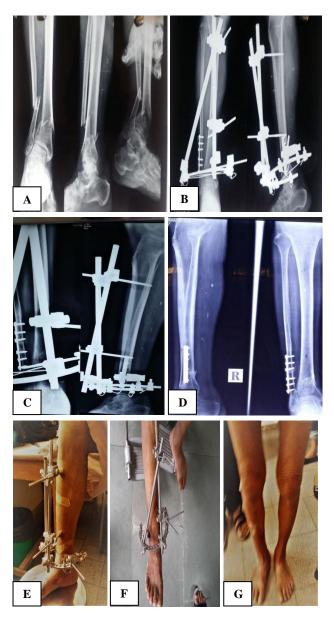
Hybrid Ilizarov fixation. A=X-ray at time of presentation; B=postoperative X-ray; C=6 weeks follow up case of patient treated with HI; D=12 weeks follow up case of patient treated with HI; E and F=assessing range of motion (ROM) during follow up of patient who underwent HI; G=patient after implant removal.
